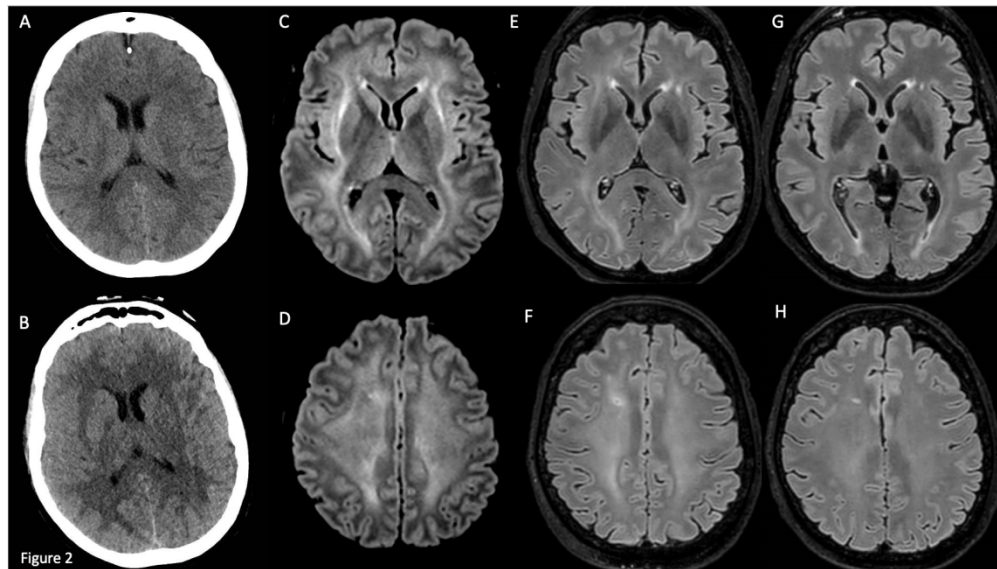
Temporal evolution of Brain Magnetic Resonance Imaging in Fulminant Cerebral Edema. Panel A: brain CT at neurotoxicity onset (day +5) resulted normal, while the next day (panel B) showed a mild diffuse white matter hypodensity and narrowing of cortical sulci suggestive for brain edema. Panel C-D: brain MRI at day +13 after CAR-T cell infusion showed diffuse vasogenic edema mainly involving the hemispheric white matter and, to a lesser extent, striatum nuclei, mesial thalamus, and pontine tegmentum, with only subtle cortical sulci effacement. Panel E-F: control brain MRI at day +26 showed a progressive reduction of vasogenic brain edema and some small periventricular white matter T2-FLAIR hyperintensity suggestive of neurotoxicity damage. Panel G-H: control brain MRI at day +96 showed a subtotal resolution of edema (C, E, G: axial FLAIR on basal ganglia level; D, F, H: axial FLAIR on corona radiata level).
